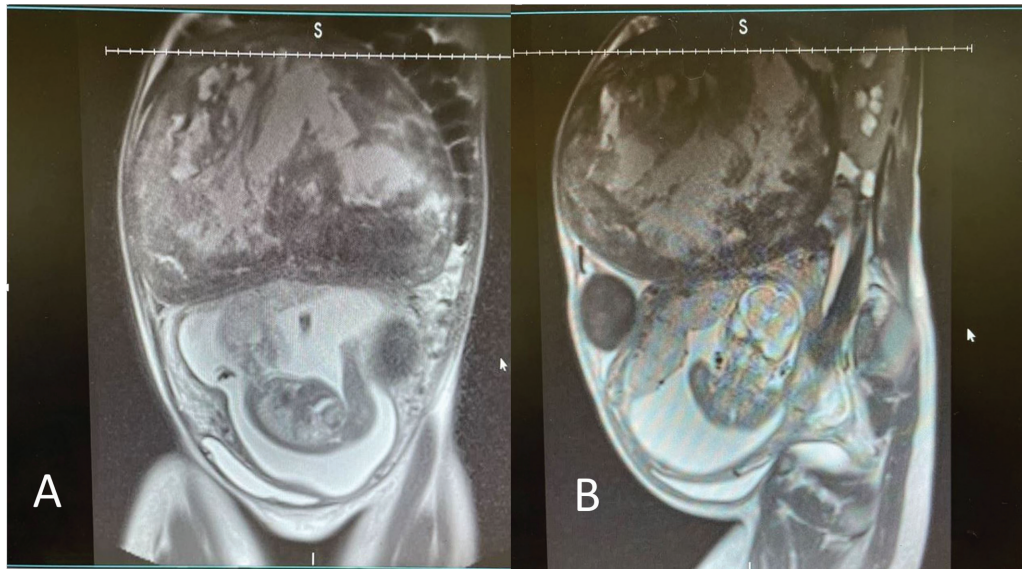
(A) Magnetic resonance imaging (coronal) showing 24 cm fibroid uterus demonstrating external compression on the fundus with live intrauterine pregnancy at 23 weeks gestation. (B) Sagittal view.
